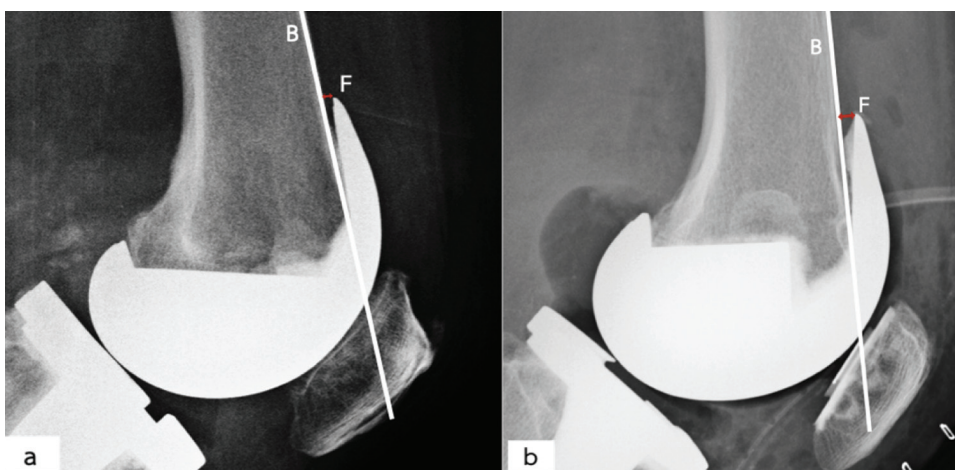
Postoperative radiographs of total knee arthroplasty with the anterior referencing system (a) and posterior referencing system (b) show the gap (F) between the tip of the anterior flange of the femoral component and the anterior femoral cortex.
